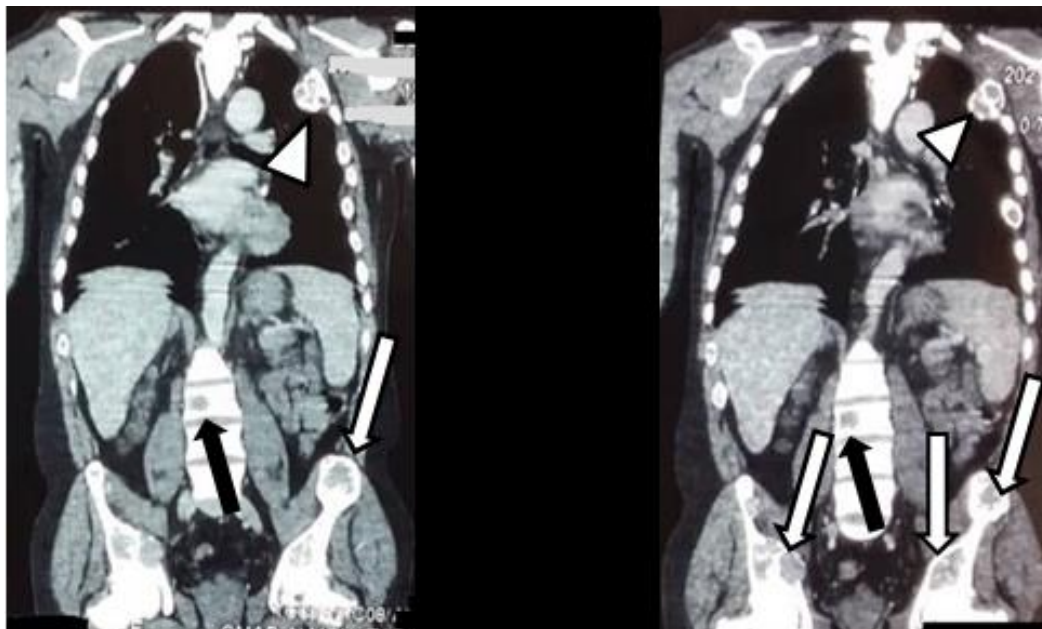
CT coronal reconstructions views; multiple lytic / mixed expansile bony lesions in pelvic (white arrow), lytic lesion in vertebrae (black arrow), and mixed expansile lesion in ribs (white arrow head).
